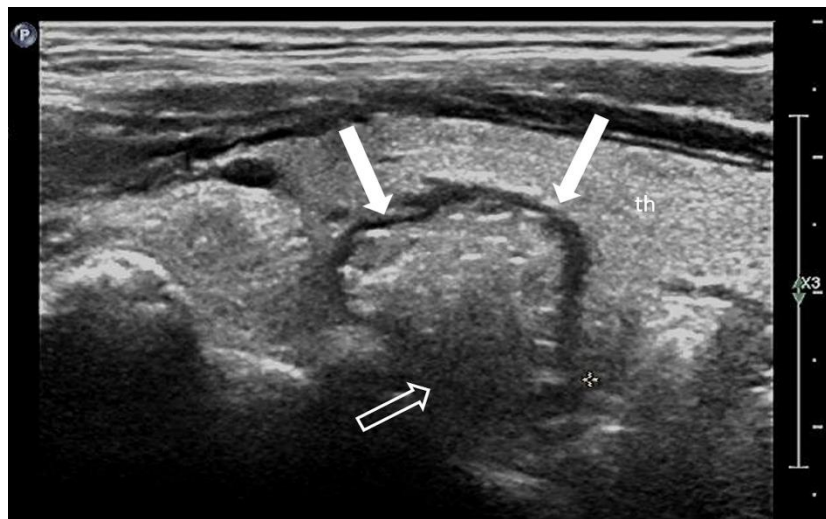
Ultrasound of the neck showing reverberation artifacts mimicking thyroid nodules, later identified as KJD.¹⁰
